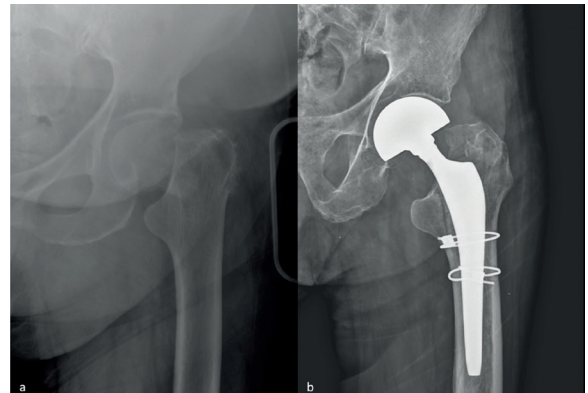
Radiographs of an 88-year-old woman with proximal femur fracture a) preoperative anteroposterior view b) early anteroposterior postoperative radiographs, intraoperative fractures were treated with two cables
